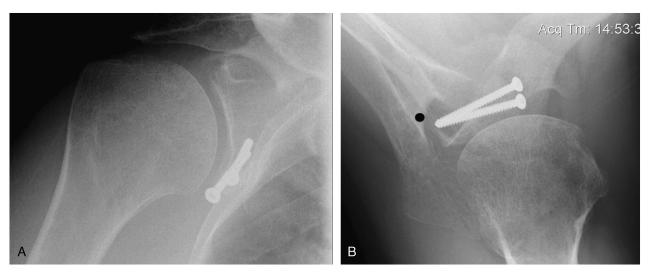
A, Postoperative anteroposterior radiograph of the right shoulder after a Latarjet procedure, demonstrating transfer of the coracoid process and conjoint tendon to the anterior glenoid, with screw fixation of the bone block onto the glenoid. B, Axillary lateral radiograph of the same shoulder, demonstrating screws passing through the bone block and from the anterior to the posterior aspect of the glenoid. The black dot demonstrates approximate location of SSN—screws penetrating through the posterior glenoid can potentially cause injury to this nerve. Images used with the permission of www.boneschool.com.
